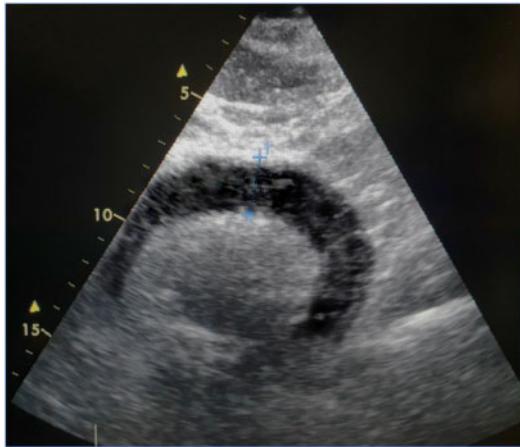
Pericardial tamponade seen in the subxiphoidal echocardiographic view.
